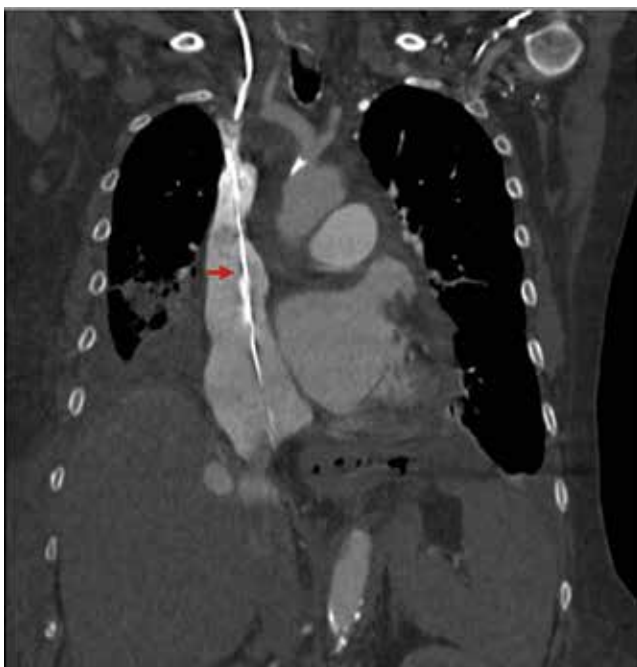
CT-chest revealing a retained guidewire within right atrium (arrow). This was removed under local anesthetic with fluoroscopic guidance via an 8 Fr. right IJ sheath with a 2.5 cm loop snare and guiding catheter.
